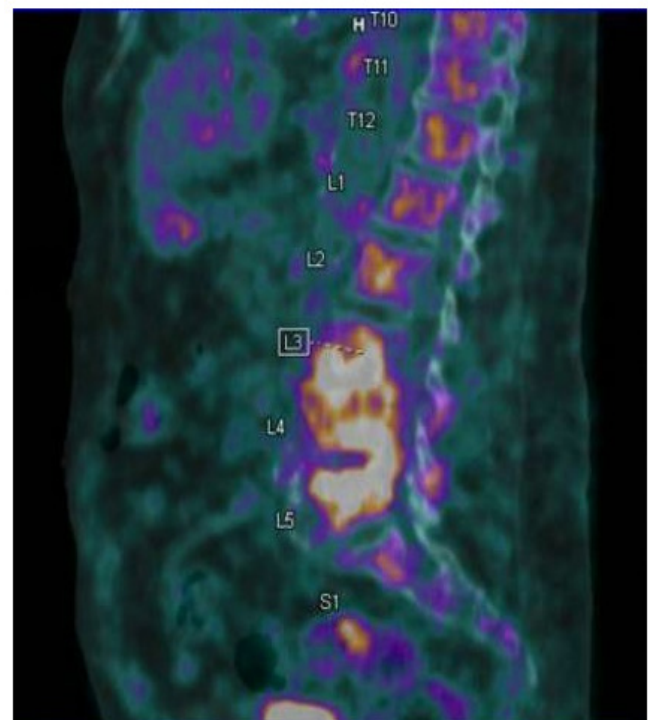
PET-CT image: Intense focal uptake in the vertebral bodies of L3, L4, and L5, suggesting possible infiltrative pathology.
